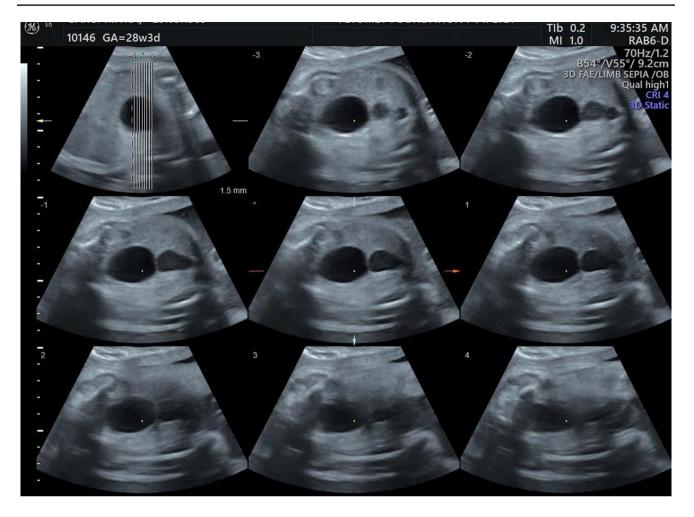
Multiplanar reconstruction in tomographic ultrasound imaging (TUI) mode demonstrating the spatial relationship of umbilical vein varix to the anterior abdominal wall (at the level of cord insertion) and fetal urinary bladder posteriorly
